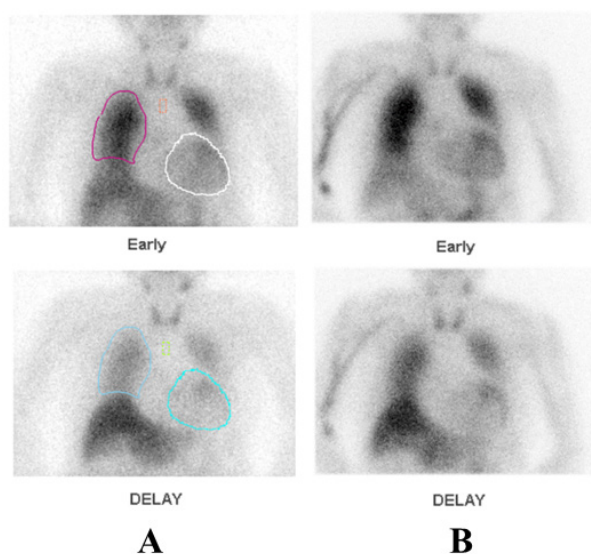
^{123}I -MIBG cardiac-scintigraphy at discharge (A) and one year after initiation of ipragliflozin (B). After administration of ipragliflozin, cardiac sympathetic nerve function improved.
